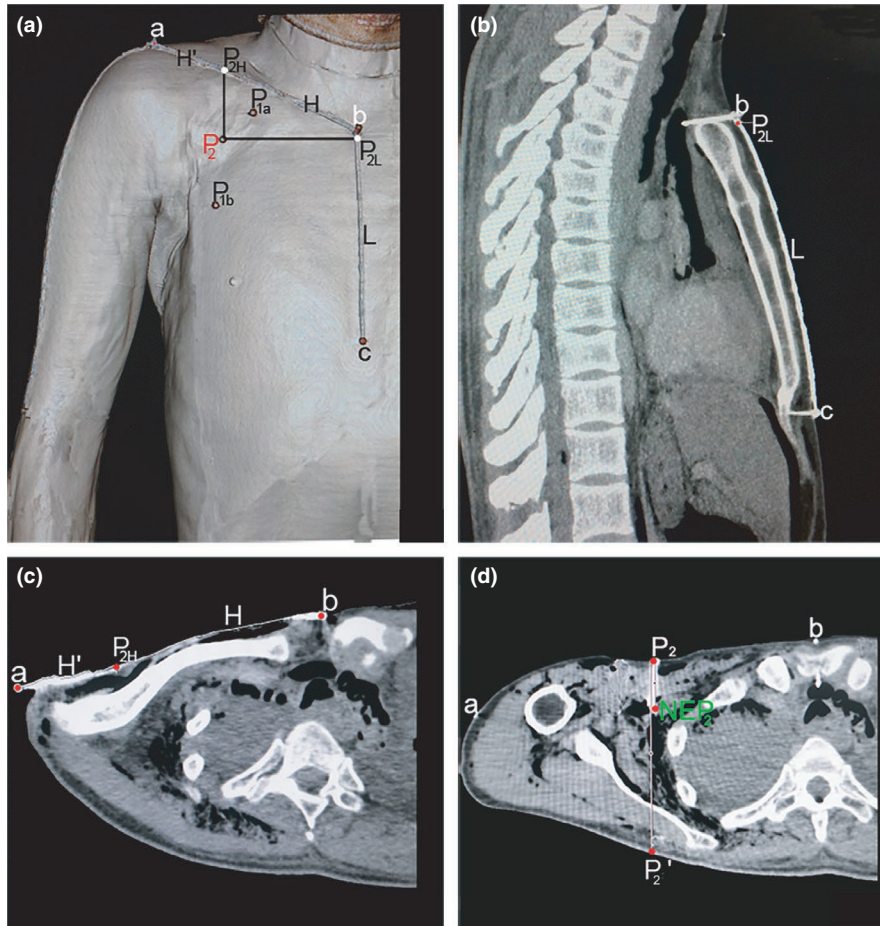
Computed tomography localization of the medial pectoral nerve entry point (NEP_2) innervating the pectoralis minor muscle. (a) The position of the NEP projection on the body surface and the design reference line. P_{1a} and P_{1b} represent the projection points of the lateral pectoral nerve and the medial pectoral nerve NEP on the body surface, respectively. P_2 is the projection point of NEP_2 on the body surface of the chest. (b) Measurement of the length of the L and L' lines in the sagittal section. (c) Measurement of the length of the H and H' lines on the cross-section through the H line. (d) Measurement of the depth of the NEP_2 on the cross-section through P_2
